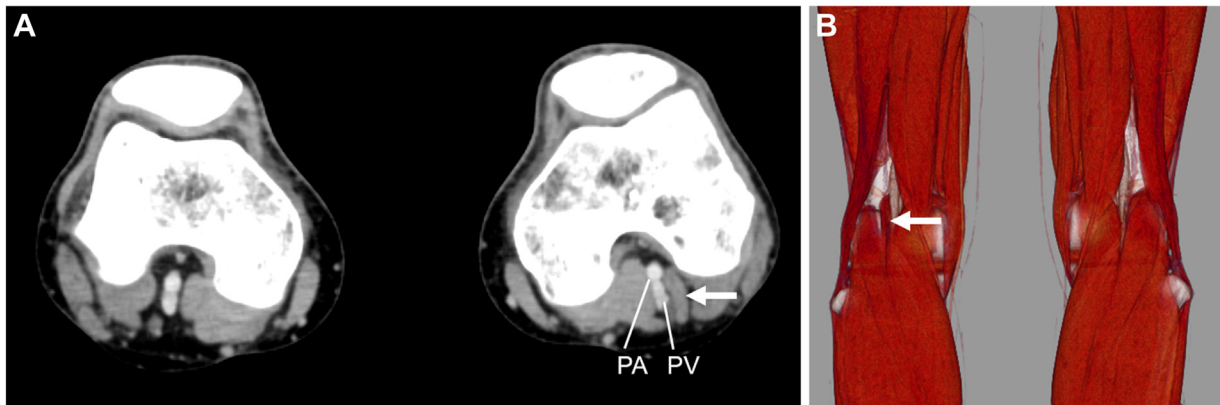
Axial (A) and three-dimensional volume rendering (B) computed tomography images showing the accessory slip of the lateral head of the gastrocnemius muscle (arrow) compressing the popliteal vein (PV). PA, Popliteal artery.
